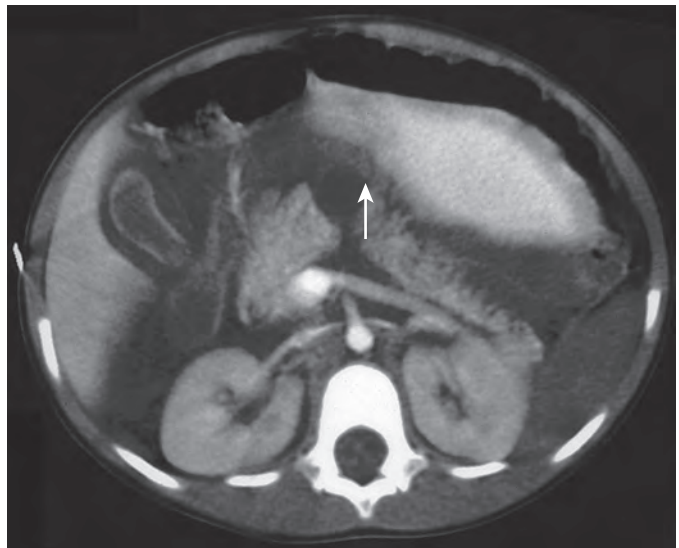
Pancreatic transection. The CT scan through the pancreas in a young child after nonaccidental trauma demonstrates complete pancreatic transection (arrow).
